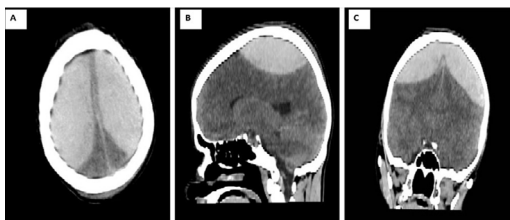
CT Head at Presentation.
